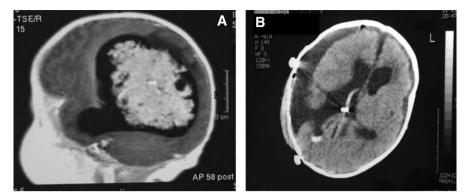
Choroid plexus papilloma in 4 year old child. A Sagittal MRI. B Post-operative CT scan
